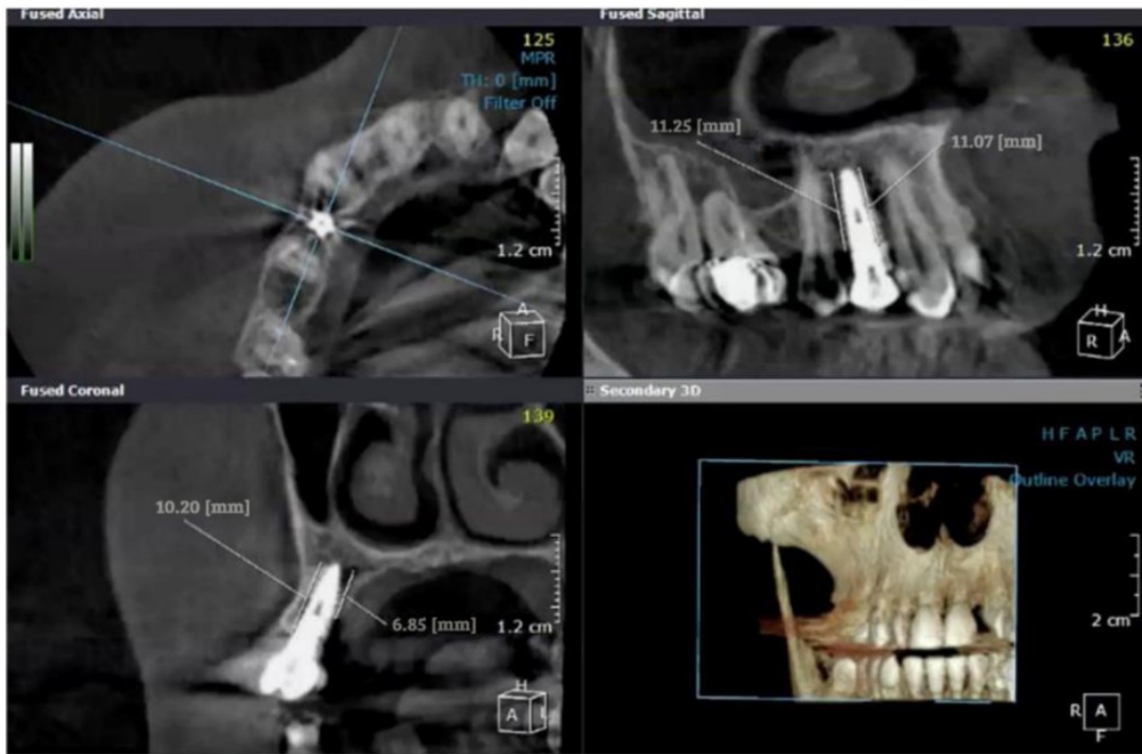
Buccal, palatal, mesial, and distal CBCT measurements at 6 months.
